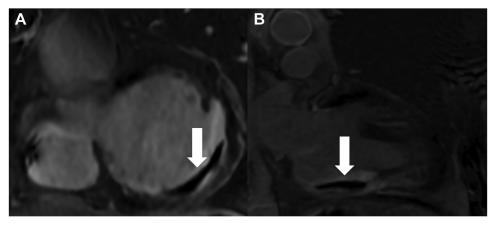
Delayed postcontrast cardiac magnetic resonance images obtained 24 hours following ventricular tachycardia ablation demonstrates curvilinear non-enhancing thrombus (*white arrow*) along inferolateral left ventricular wall in the region of the recent ablation. A: Short-axis orientation. B: Two-chamber orientation
